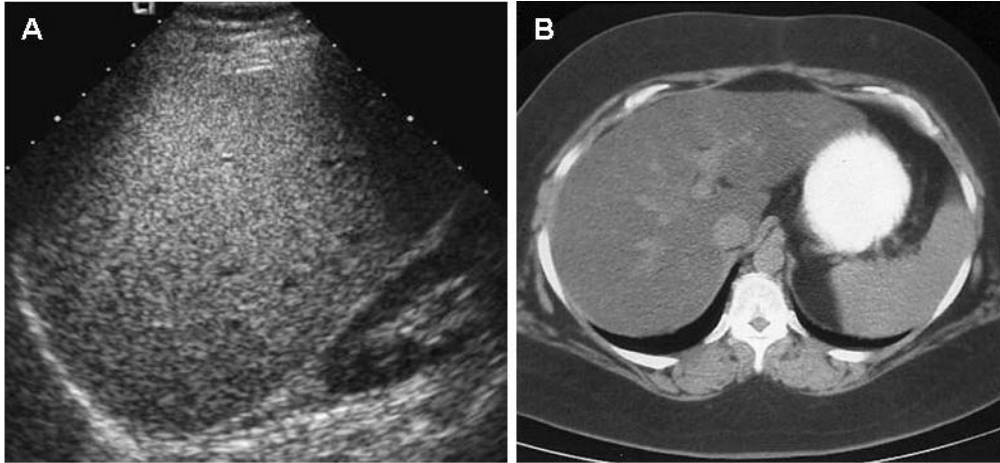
(A) The ultrasonographic findings of diffuse fatty change in the liver are a diffuse hyperechotexture (bright liver) compared with the kidney and vascular blurring. (B) Non-enhanced CT scan through the liver of a patient with fatty infiltration showing low attenuation of the hepatic parenchyma in comparison with the hepatic vasculature giving the appearance of a contrast-enhancement in a noncontrast-enhanced scan.
